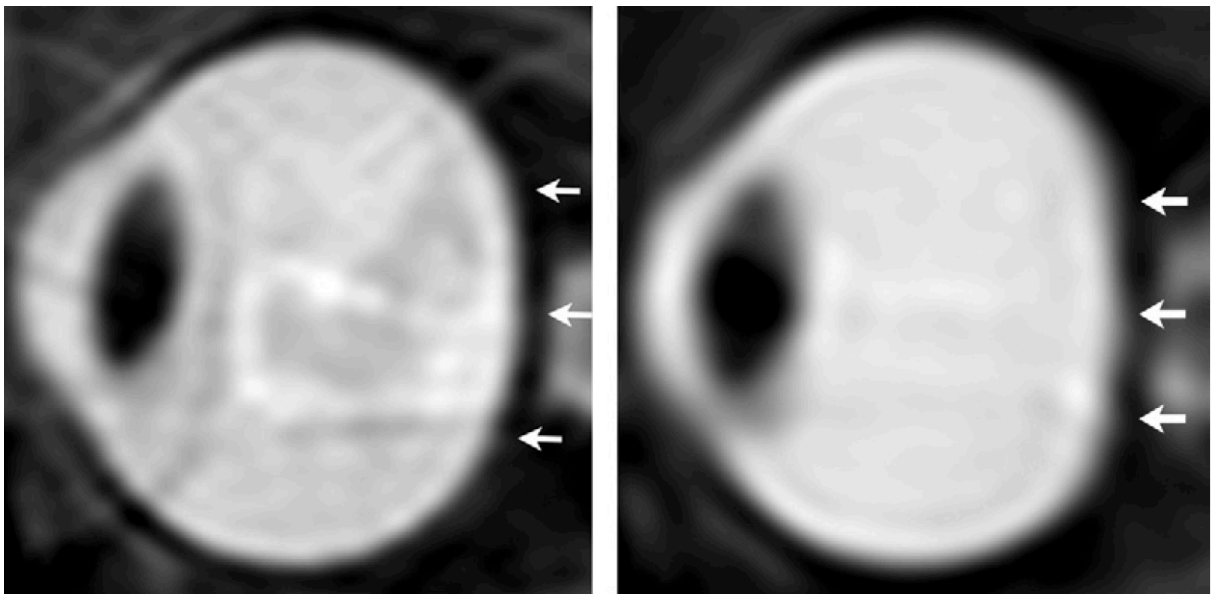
Sagittal T2 weighted MRI subjectively showing posterior globe flattening after spaceflight (right)¹⁴.
